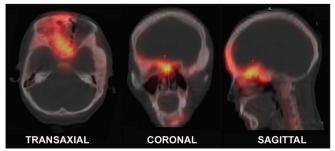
Hybrid SPECT/CT fusion to determine the extent of skull and facial bone involvement shows intense tracer uptake in the sphenoid, ethmoid and frontal bones
